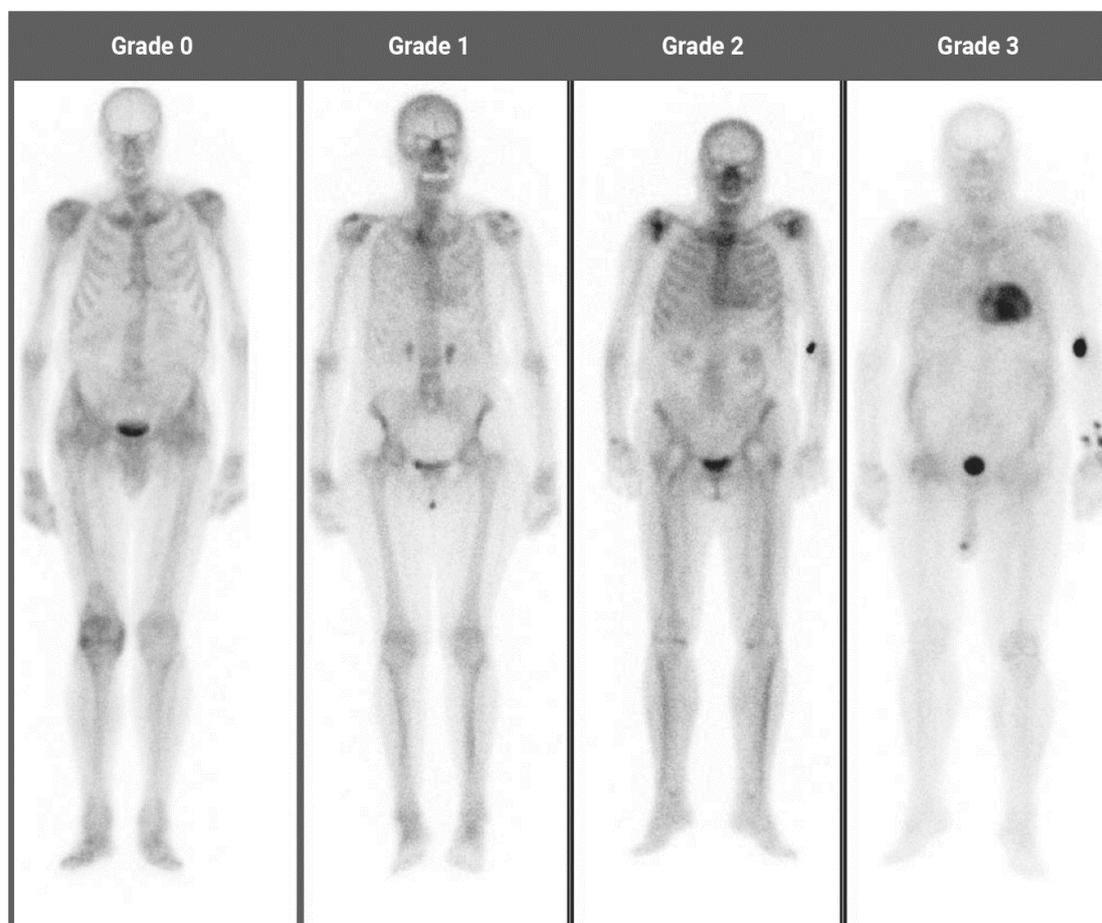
Showing cardiac uptake grading by bisphosphonate scintigraphy.
